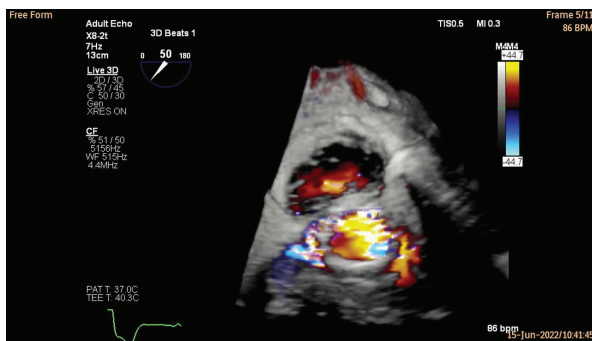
3D Color transoesophageal echocardiography – SAX visualization of paravalvular leak
